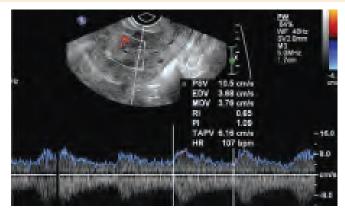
Pulsed Doppler waveform analysis of endometrial hyperplasia. Note moderate vascular impedance blood flow signals with RI of 0.65
